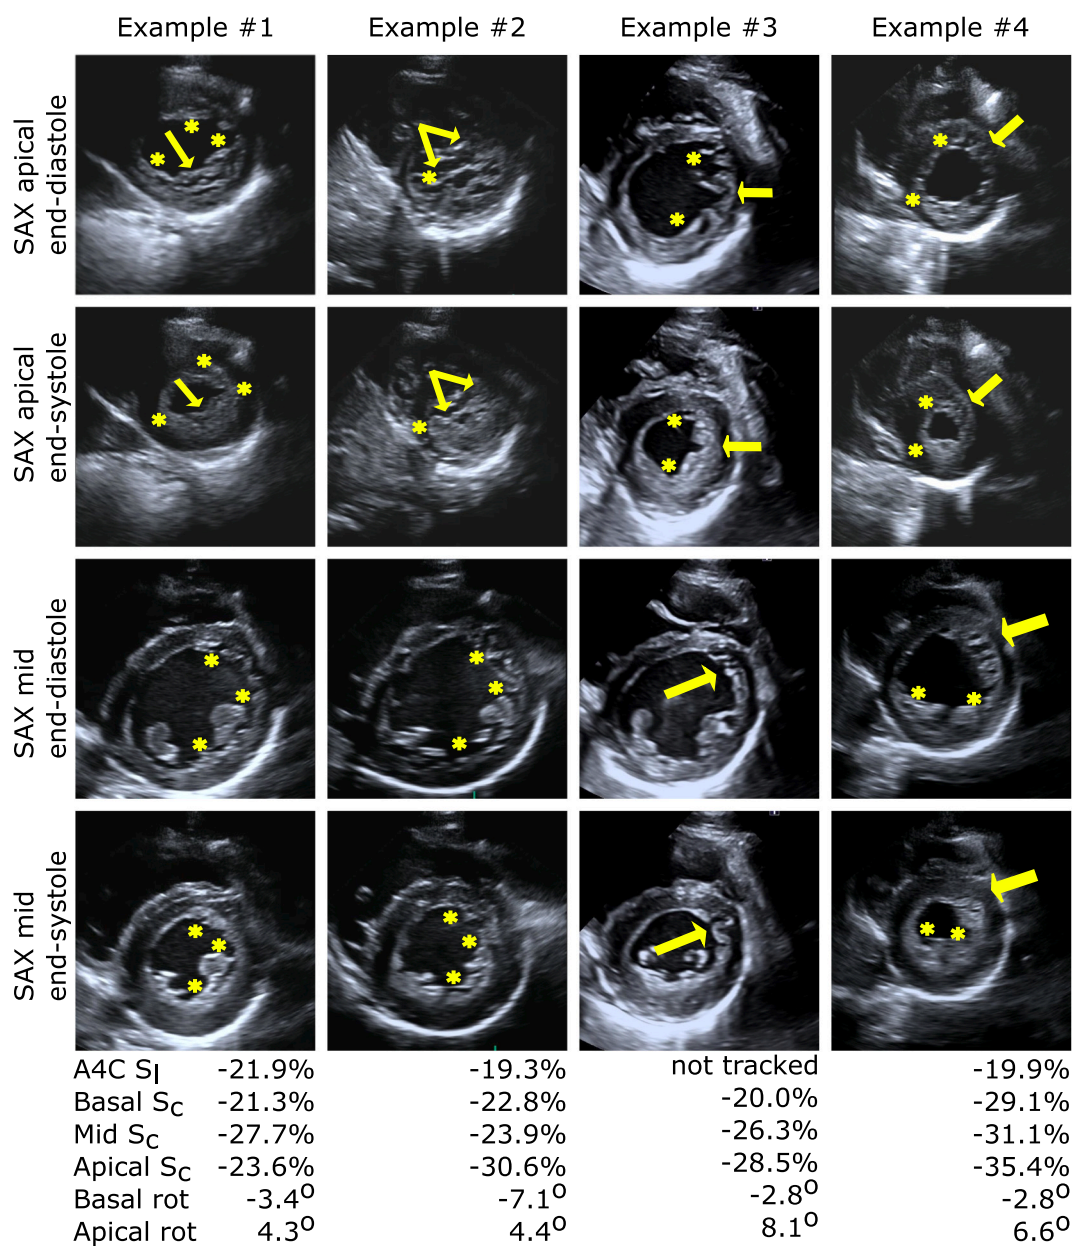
Examples of athletes meeting the left ventricular non-compaction criteria [8]. Each column represents one example (#1-#4) and shows the short axis (SAX) apical and mid views (in end-diastole and end-systole), as well as peak systolic longitudinal apical 4 chamber (A4C) strain ( $S_l$ ), circumferential strain ( $S_c$ ), basal rotation (Rot) and apical rotation (Rot). Arrows point to the myocardial segments with hypertrabeculation having an end-systolic non-compacted/compacted (NC/C) ratio  $\geq 2$ , while asterisks show segments with hypertrabeculation and a NC/C ratio  $< 2$ .
